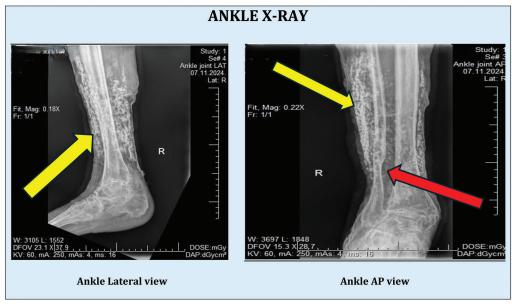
X-ray diagnostic of the right ankle lateral (LAT) and anterior posterior views. Yellow arrow showing diffuse soft tissue calcifications embedded within muscles of the soft tissue. The red arrow indicates old spiral fracture of the ankle
